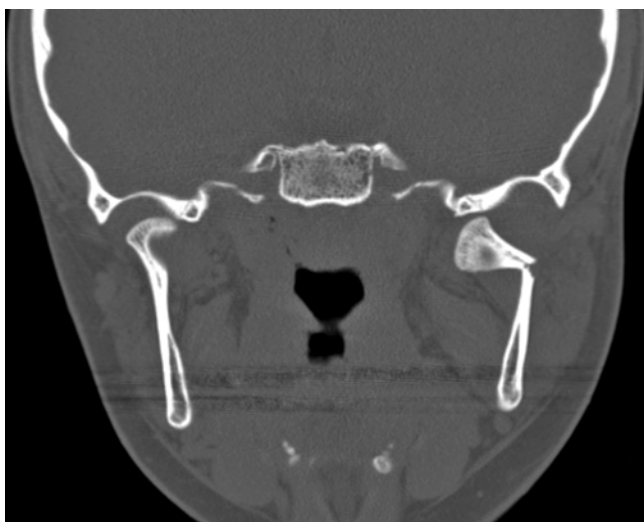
Coronal CT demonstrating left condylar neck fracture
